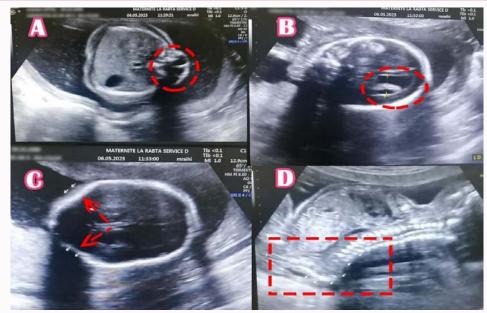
1D: Ultrasound showing fetal spina bifida.
